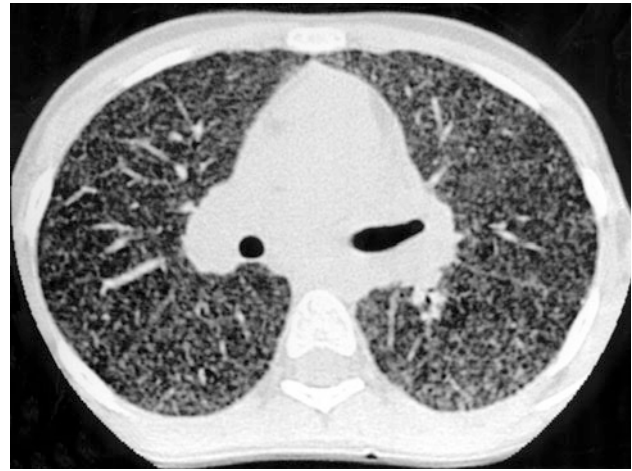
A 10-month-old female infant with biopsy-proven nonspecific interstitial pneumonitis. HRCT shows ground glass and honeycombing. [Reprinted with permission from Copley et al. (2000)]
